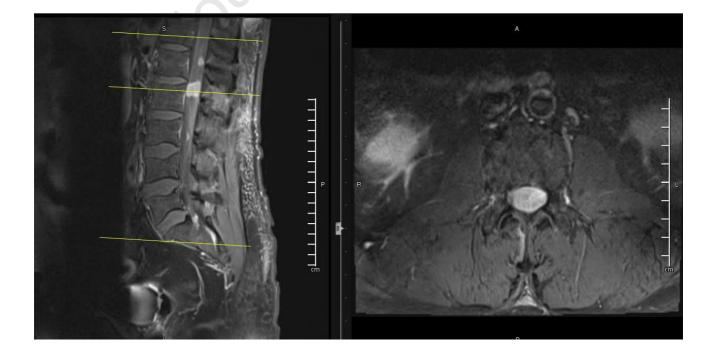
MRI T1 with gadolinium enhancement sagittal and axial Lumbar level showing multiple intradural , intraspinal metastasis with largest one at level of L2
